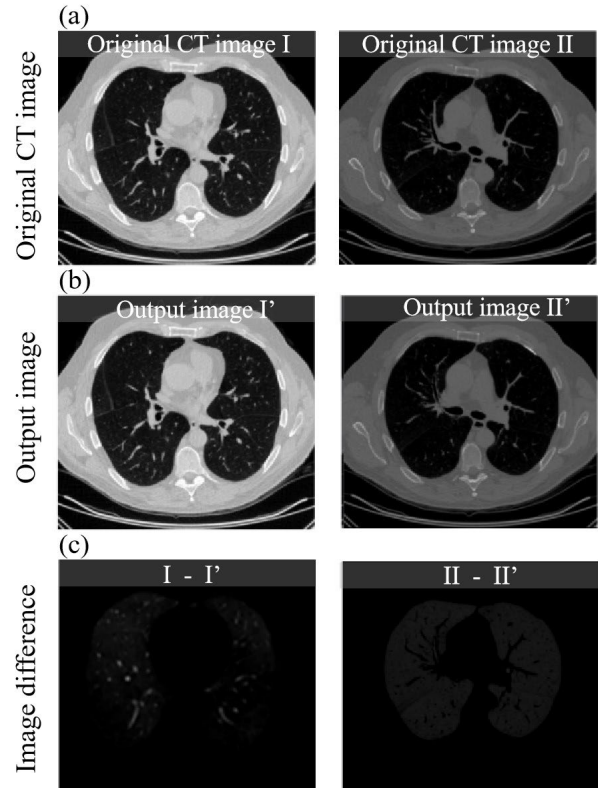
Comparison of output and input of self-supervised feature extraction model. (a) represents two different original CT image, (b) represents their output respective, (c) represents the difference between the original and output image.
